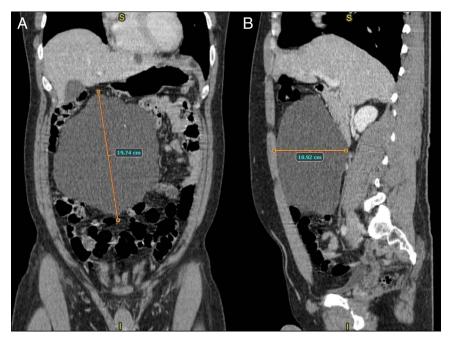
Computed tomography (A) coronal view and (B) sagittal view showing the mesenteric cystic lymphangioma.
